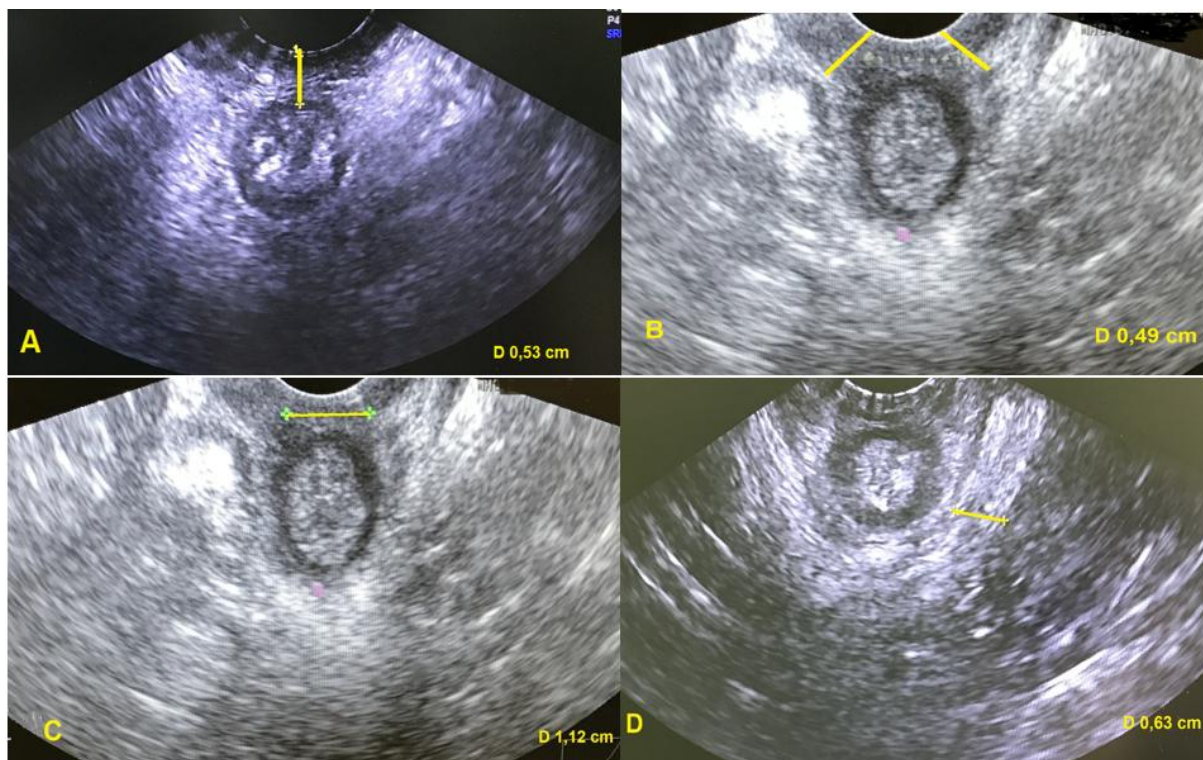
Pelvic floor disorder. Transperineal ultrasound scanning showed decrease in the height of the centrum tendineum (A, marked by yellow arrow), the width of m. bulbocavernosus (B, yellow arrow); the diastasis of m. bulbocavernosus and decrease the width of m. puborectalis (D, yellow arrow).
